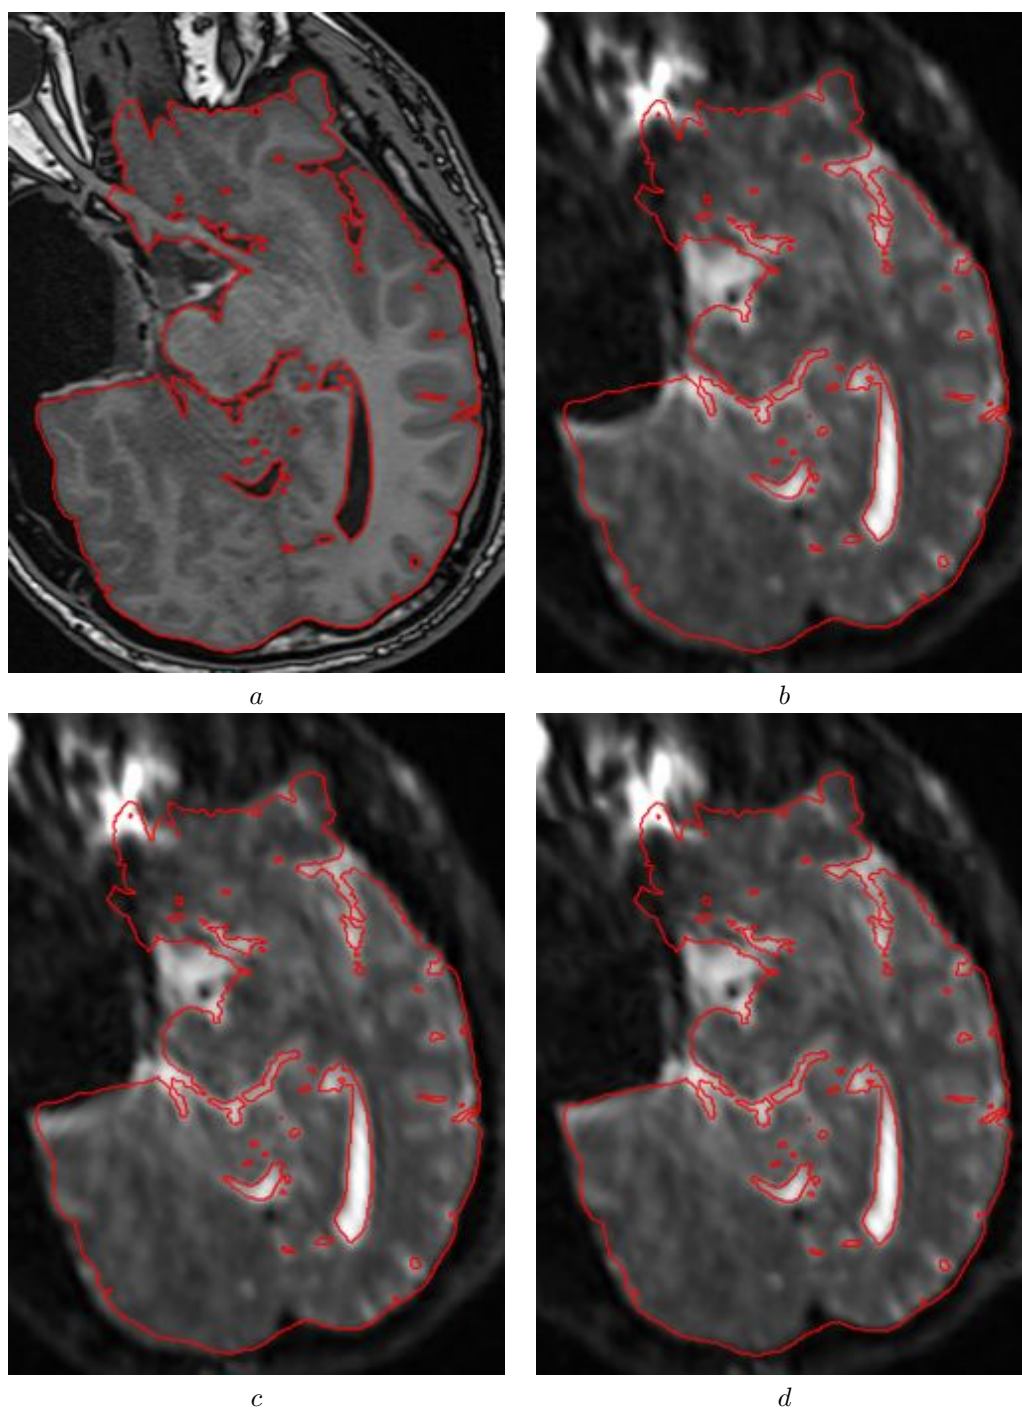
Images showing the result of correcting for susceptibility-induced spatial distortion using our algorithm. (a) shows the gold-standard high resolution T1-weighted image acquired during surgery. (b) shows the uncorrected B0 image with a large geometric distortion around the resected area. (c) shows the result of correcting for susceptibility artefacts using the proposed fieldmap estimation. (d) shows further improvement in the result when combined with the image registration step.
